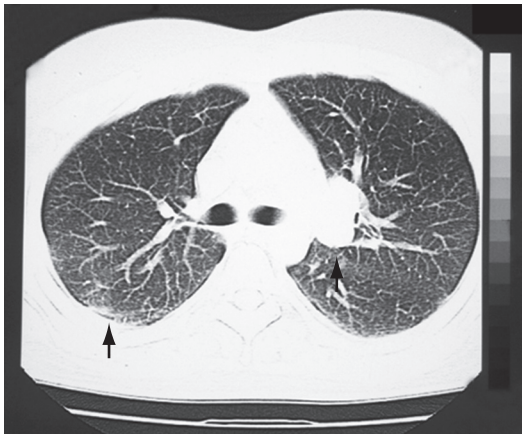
Chest CT scan revealing peripheral condensation with right pleural involvement and left hilar lymph node enlargement.
